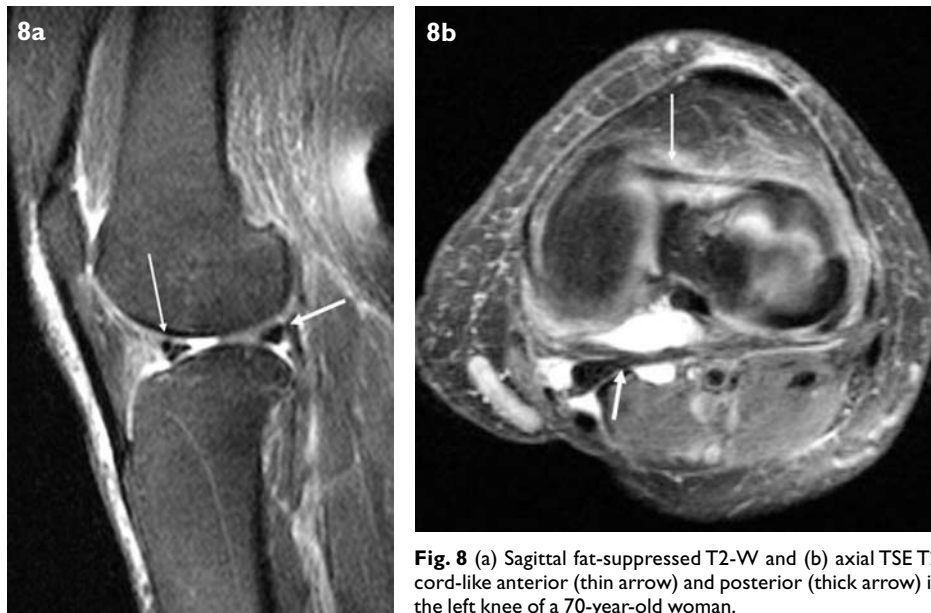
(a) Sagittal fat-suppressed T2-W and (b) axial TSE T2-W MR images show a cord-like anterior (thin arrow) and posterior (thick arrow) intermeniscal ligament in the left knee of a 70-year-old woman.
